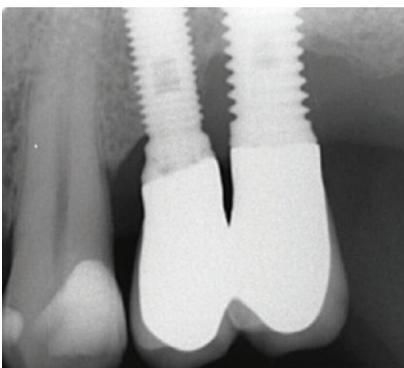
Case 2 - 12 months radiograph.
